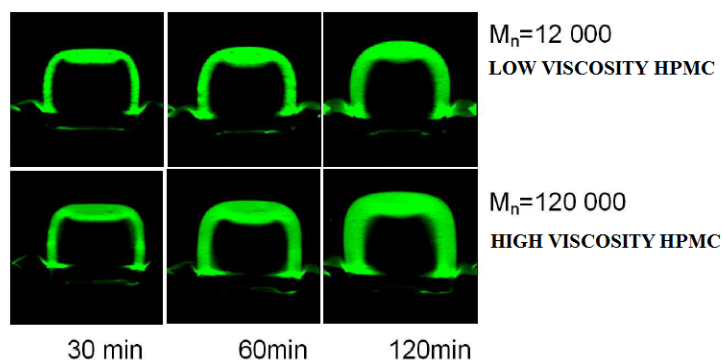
Atypical two-dimensional MR images of swollen HPMC tablets after different times of swelling (pH = 2) (taken from Tritt-Goc and Kowalczyk 2005).
